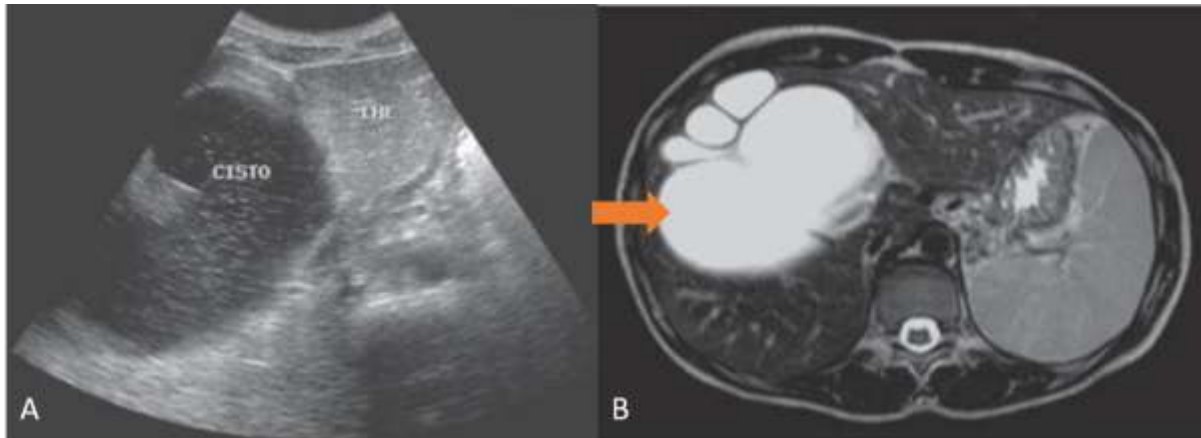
A case of 7-year-old female diagnosed of choledochal cyst Type IA, On ultrasound (a) showing a well-defined cystic lesion containing thin septa and hyperechoic echoes adjacent to the right hepatic lobe, in the gallbladder fossa and on MRCP T2 HASTE image (b) demonstrating cystic lesion with regular contours.
